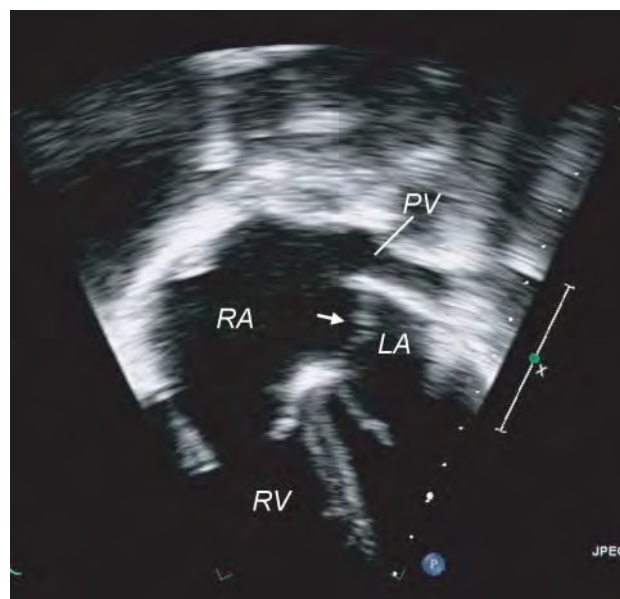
Anomalous pulmonary venous drainage. Apical two-dimensional echocardiogram image in a patient with severe leftward malposition of septum primum shows the lack of septum secundum superiorly, normal pulmonary venous connections to the posterior aspect of the left atrium (LA), and leftward malposition of septum primum (arrow), resulting in drainage of all pulmonary veins into the right atrium (RA). PV, pulmonary veins; RV, right ventricle.
